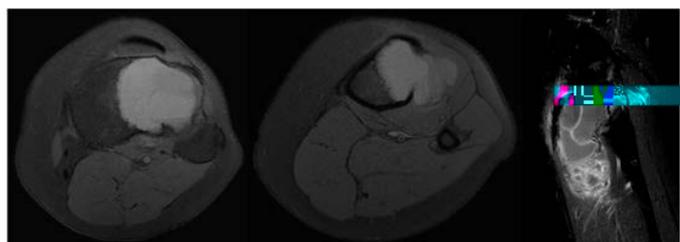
Giant cell tumor, male, 19 years old, distal fibula, type IC (radiography and MRI), fluid-fluid level >2/3, solid component, perosteal reaction, no fracture. Score 4.
